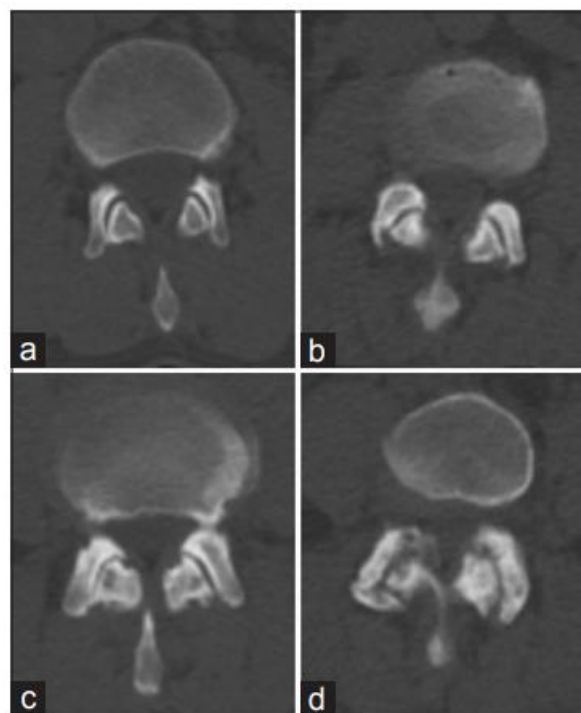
CT images of progression of FJ arthropathy showing narrowing joint space narrowing, osteophytes, hypertrophy, bony erosions and sub-chondral cysts.<sup>45</sup>
